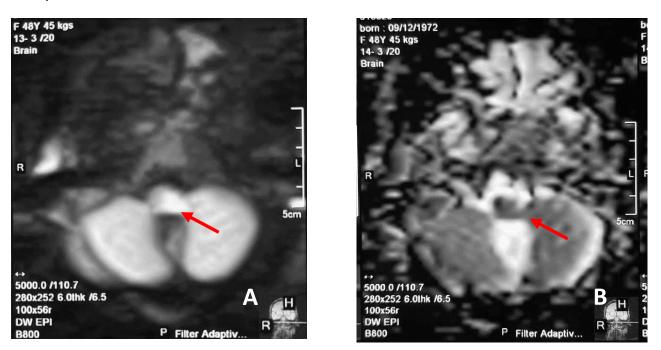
(A) Cranial MRI Diffusion-weighted imaging (DWI) Axial view showing a hyperintense lesion in the left lateral medulla oblongata signifying an acute stroke (red arrow). (B) Cranial MRI ADC Images with equivocal signal in the left lateral medulla (red arrow).
